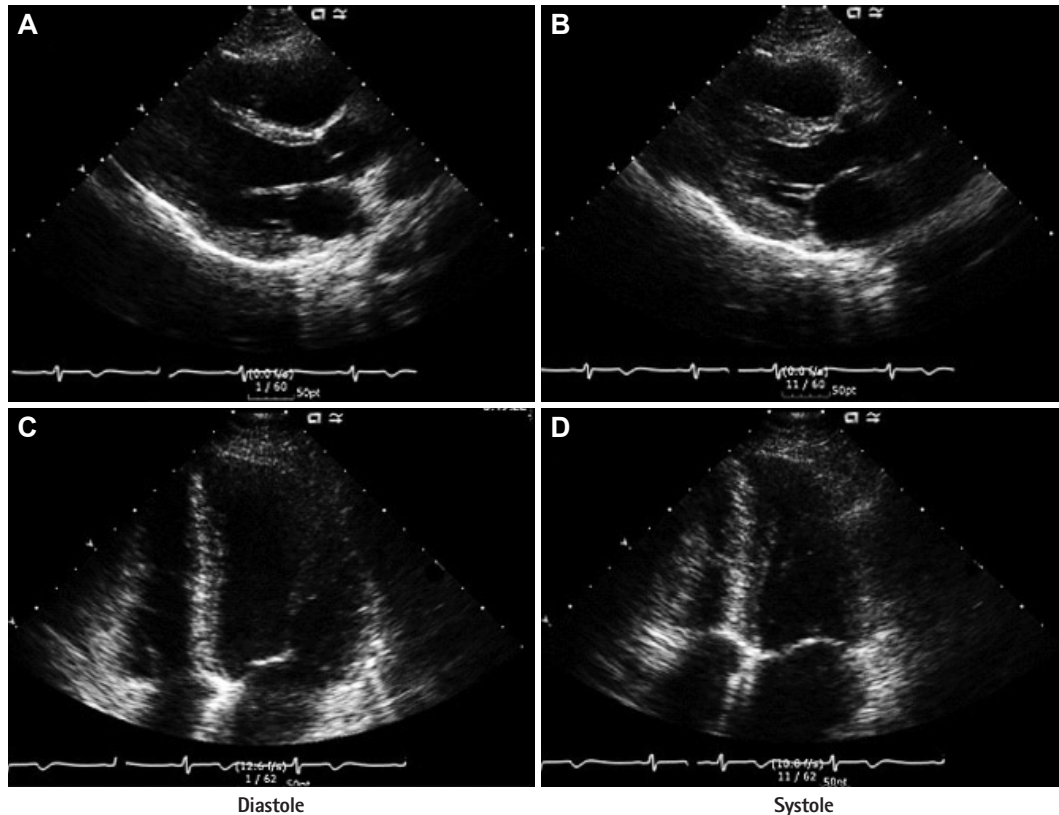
A follow-up echocardiography 1 week later shows improved base and mid portions of ventricle and nearly normalized cardiac functions. A and B: parasternal long-axis view in diastole and systole. C and D: apical four-chamber view in diastole and systole.
